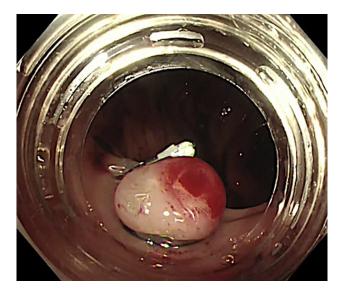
Endoscopic band ligation performed at the site of the positive Doppler wave.
